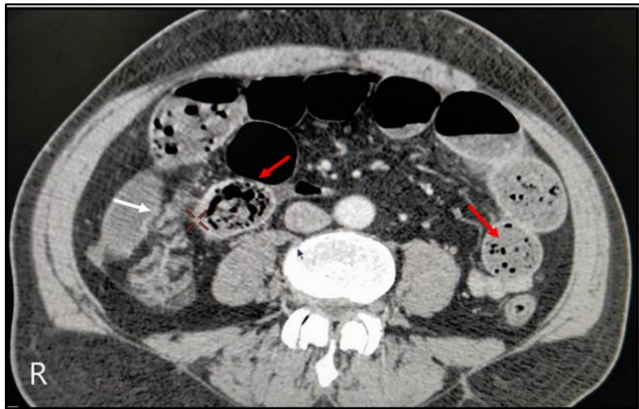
Axial View CT Abdomen showing transition point (white arrow), dilatation and faecalistaion of small bowel (red arrows)
